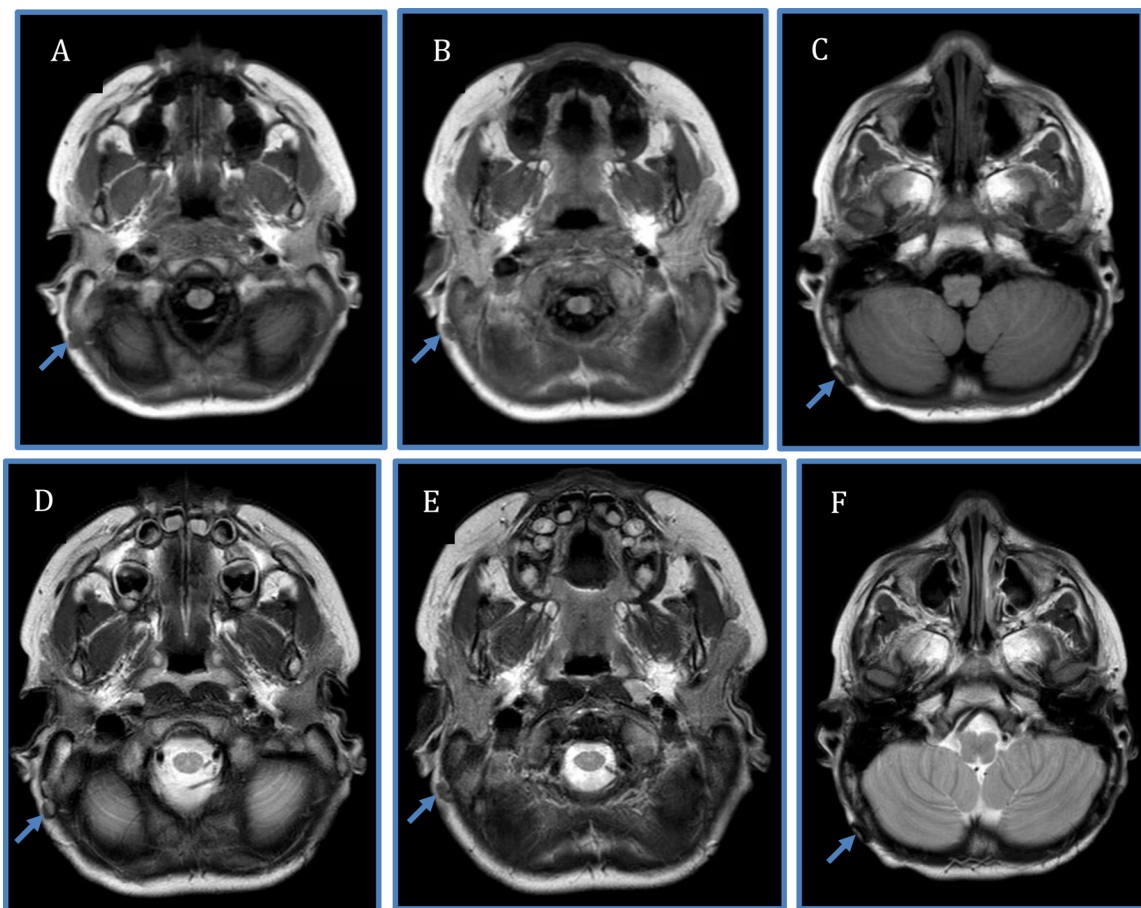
(A, B) – Axial T1-weighted MRI demonstrating ovoid, soft tissue nodules/lymph nodes; (C) Axial T1-weighted MRI demonstrating glass shard; (D, E) Axial T2-weighted MRI demonstrating ovoid, soft tissue nodules/lymph nodes; (F) Axial T2-weighted MRI demonstrating glass shard.
